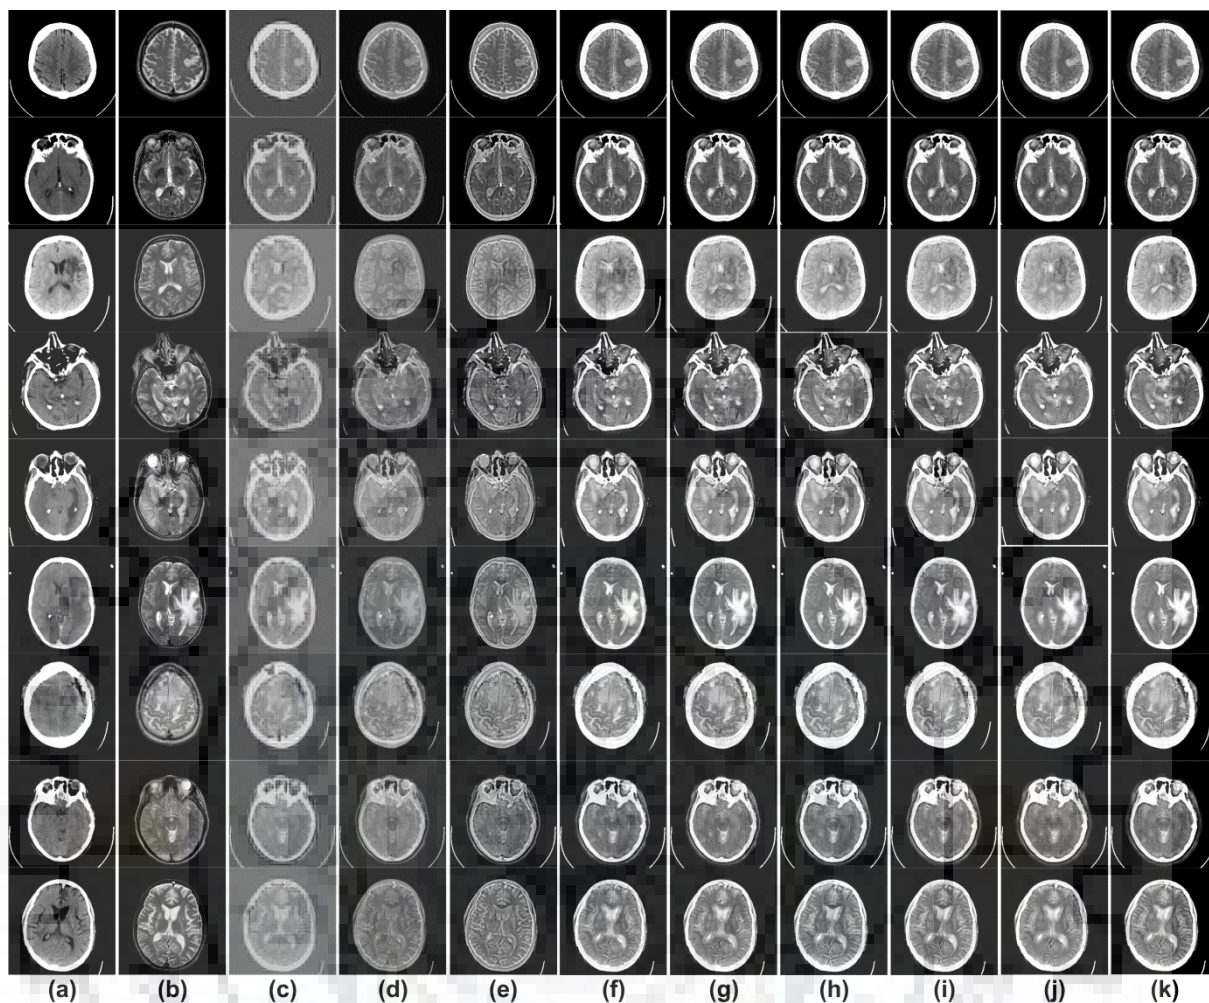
Comparative results of the different fusion methods applied to the source (a) CT images and (b) MR images. Rest of the columns show the fused image produced by the (c) Method 1 (d) Method 2 (e) Method 3 (f) Method 4 (g) Method 5 (h) Method 6 (i) Method 7 (j) Method 8 (k) Proposed NSST-MIF method
